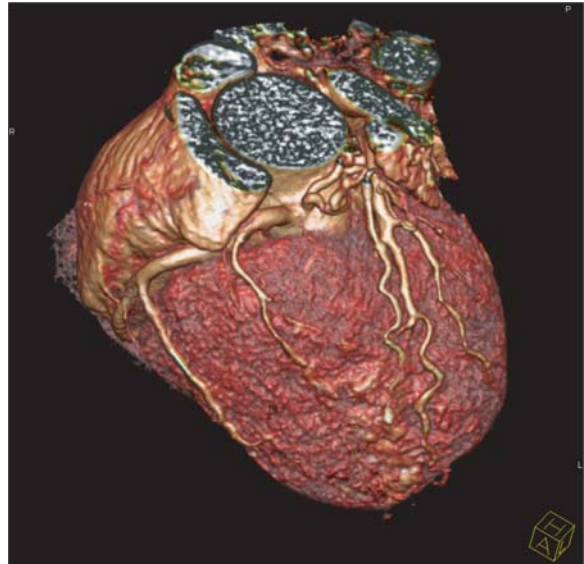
64-slice CT examination of a patient with chest pain. No β -blocker medication was used and the patient had a heart rate between 71 and 78 bpm during the scan. The entire coronary artery tree can be readily assessed despite the higher heart rate
